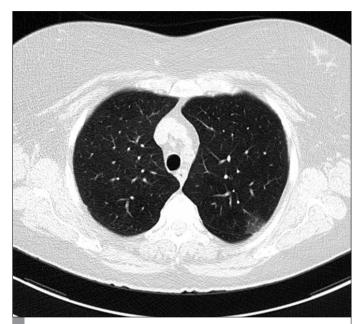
CT scan from a 73-year-old female former smoker. The CT shows a ground glass density lesion that is not visible on chest radiograph. This lesion was resected 15 months after this CT scan and proved to be adenocarcinoma *in situ* (Stage 0).
